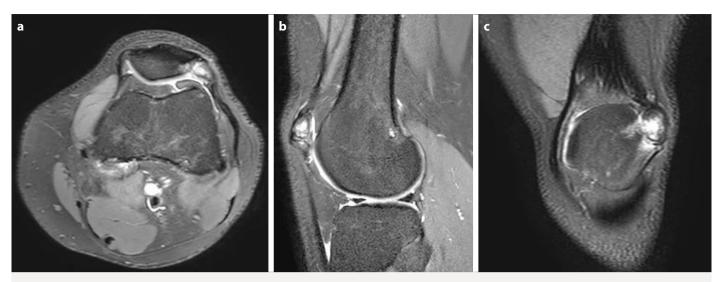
(a) Axial and (b) sagittal Proton density weighted (PDW), (c) coronal T2 weighted MR images show bone marrow edema within the bipartite patella and adjacent area to synchondrosis.
